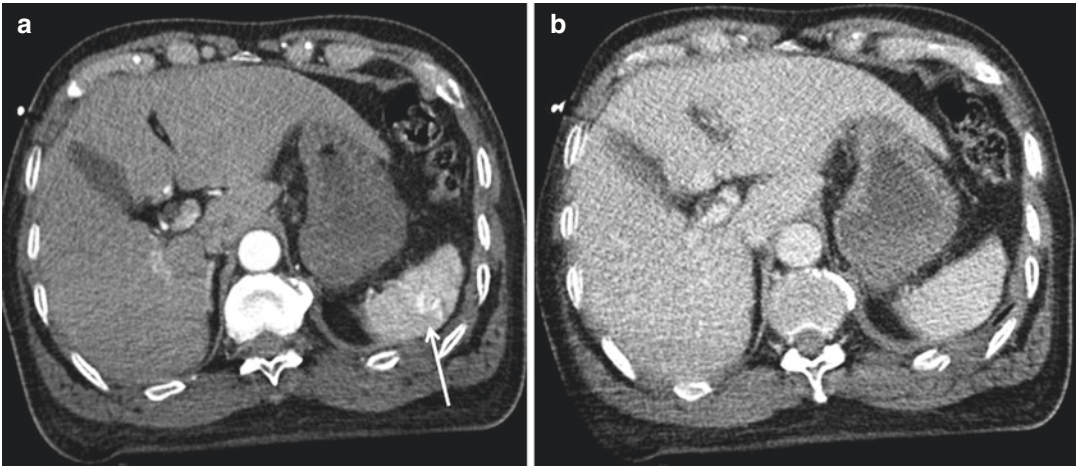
Arteriovenous fistula. Multiphase CT study shows a small arteriovenous fistula at the upper splenic pole (*arrow*): the dynamic study is essential as it shows the classical sign of a contained vascular lesion that is a
